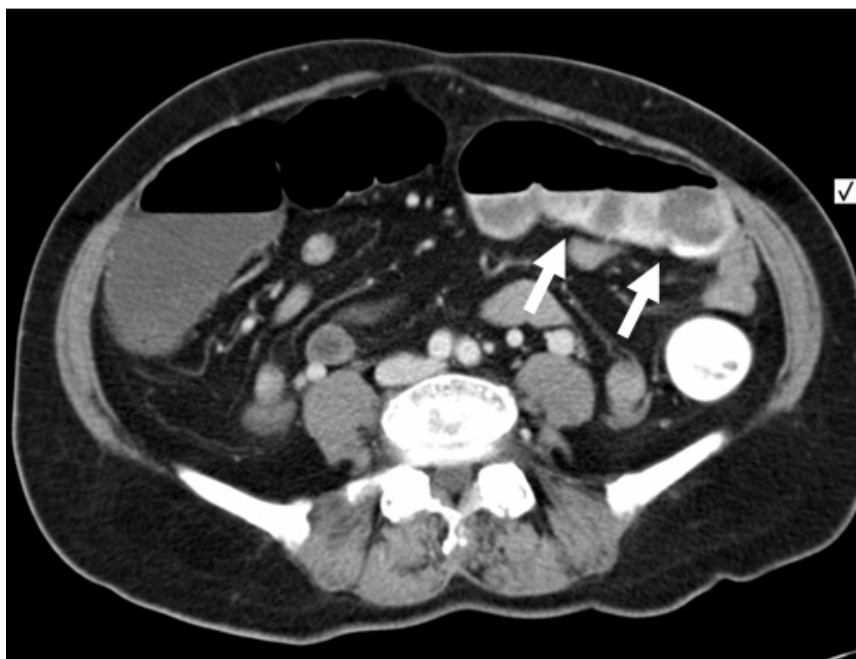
Axial computed tomography imaging showing dilated colon and bezoars (arrows).
